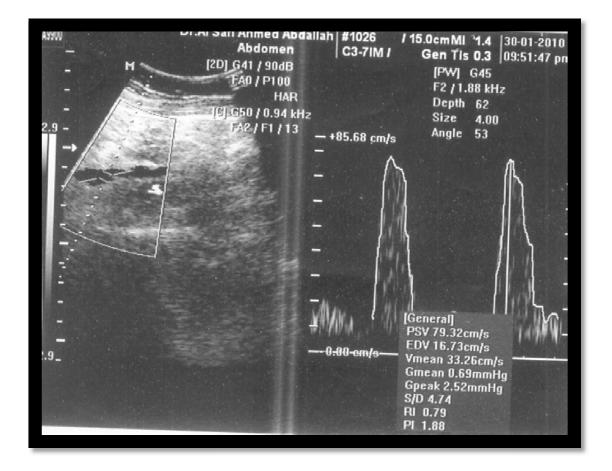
Color Doppler abdominal scan Showing complete abortion for a 41 patient with history of (RPL) .
